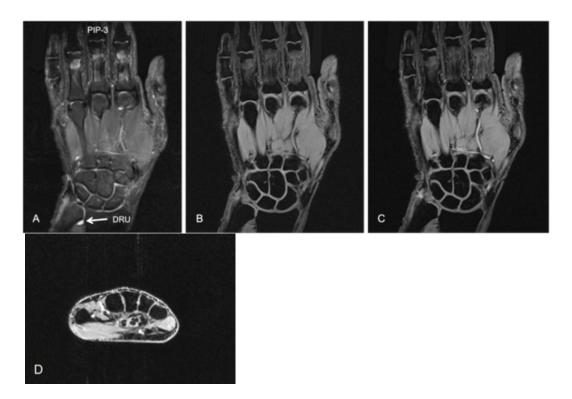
Acceptable image quality. Coronal STIR (A), T1-weighted fat-suppressed 3D GRE pre- and post-contrast (B-C), and post-contrast axial 3D GRE (D). Note complete anatomical coverage (in-plane) from the DRU proximally to PIP-3 distally; homogeneous signal and fat suppression on images B-D, high contrast-to-noise ratio, no artifacts, and sharp delineation of articular cartilage on fat-suppressed 3D GRE (B).
